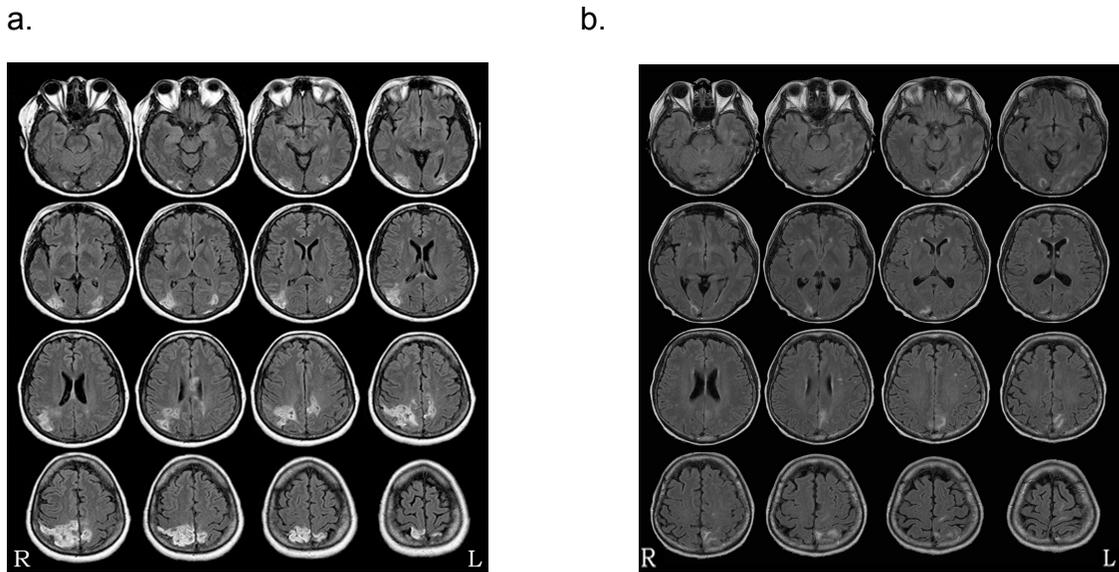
Axial FLAIR sequences of MRI scans of a) patient SL, and b) patient ES. White areas indicate hyperintense signal in damaged brain regions. R = Right, L = Left side of the brain.
